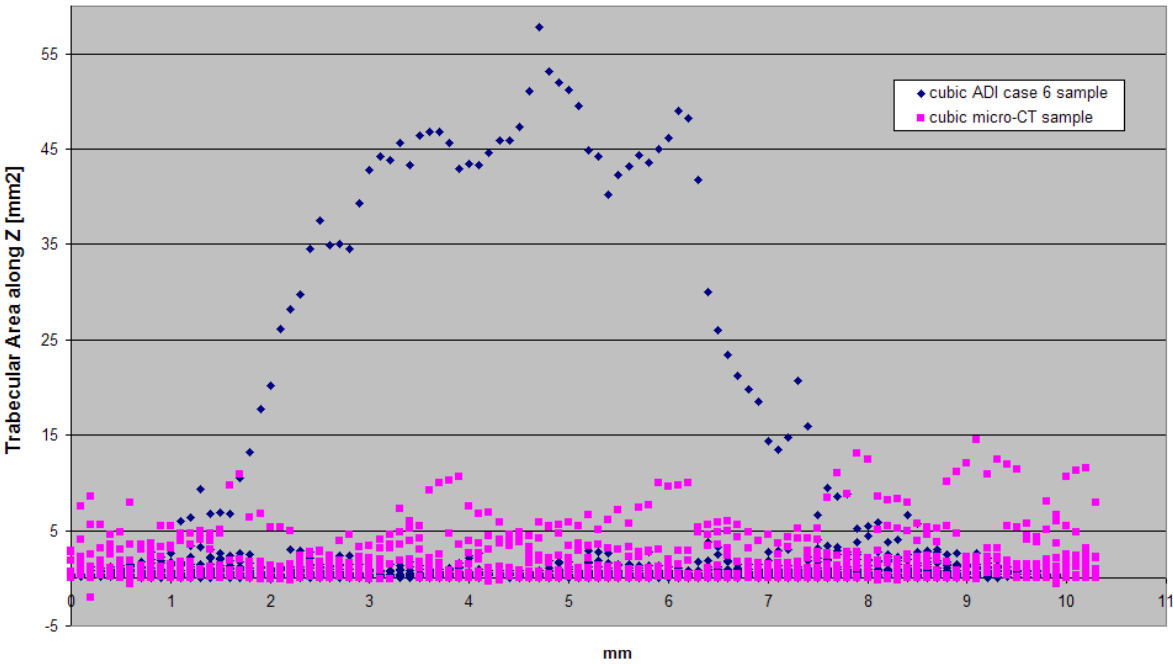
Comparison of sliced area along  $Z$  between the cubic ADI case 6 sample and cubic  $\mu$ CT sample
